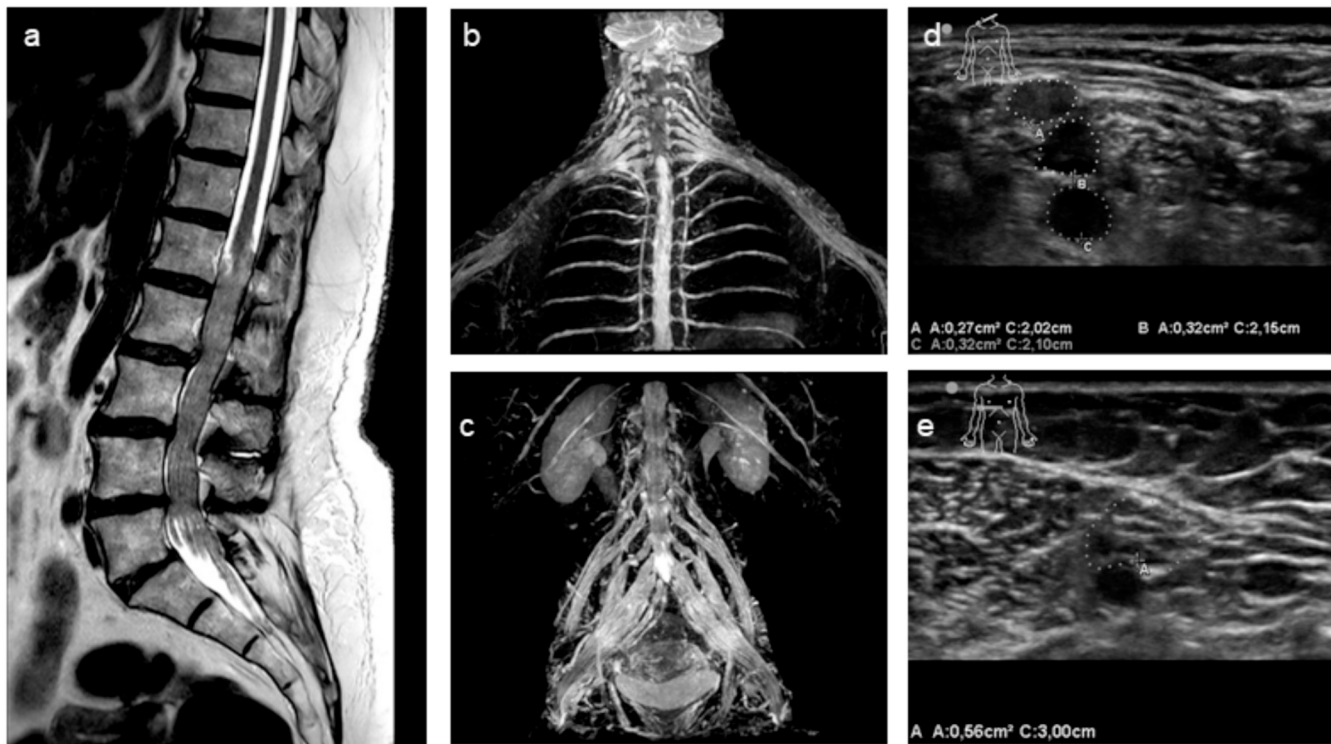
Nerve, Roots and plexus MRI or/and ultrasonography of case 4 (family 2).
